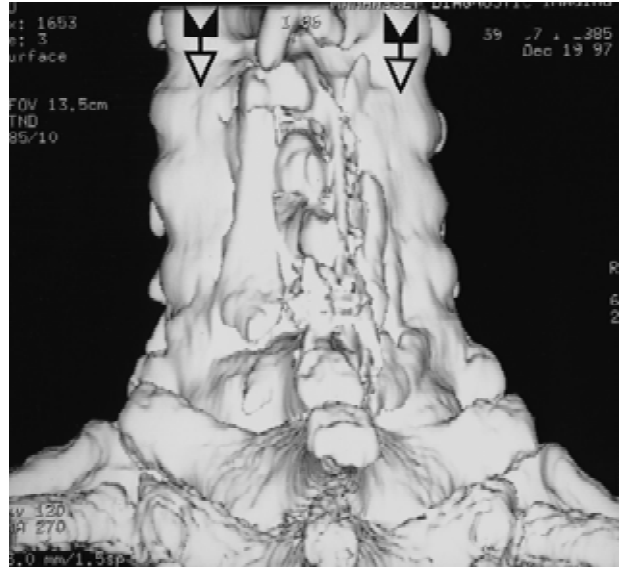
A three-dimensional coronal CT shows solid fusion 1.5 years after C3–C7 PWF (case 1). On this three-dimensional coronal CT scan obtained 1.5 years after a C3–C7 spinous process, braided cable wiring and autograft fusion, solid fusion masses (arrows) may be visualized bilaterally fully covering the facet joints and the laminae.
